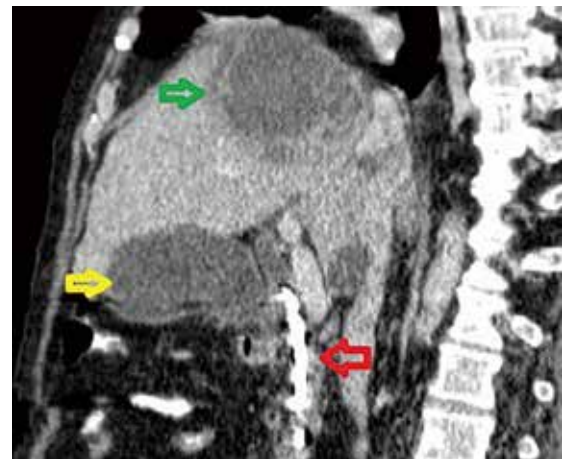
Hepatic abscess, stent in CBD and gallbladder. CT of the abdomen depicting the hepatic abscess, the stent in CBD and the gallbladder. The green arrow is demonstrating the hepatic abscess, the red arrow is depicting the stent in CBD and the yellow arrow is showing the gallbladder.
